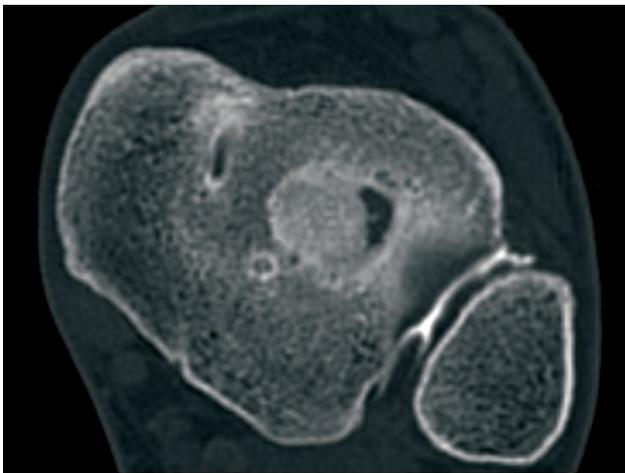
Axial computed tomography of ankle. The recurrent lesion is located on the anterolateral side of the first graft.
